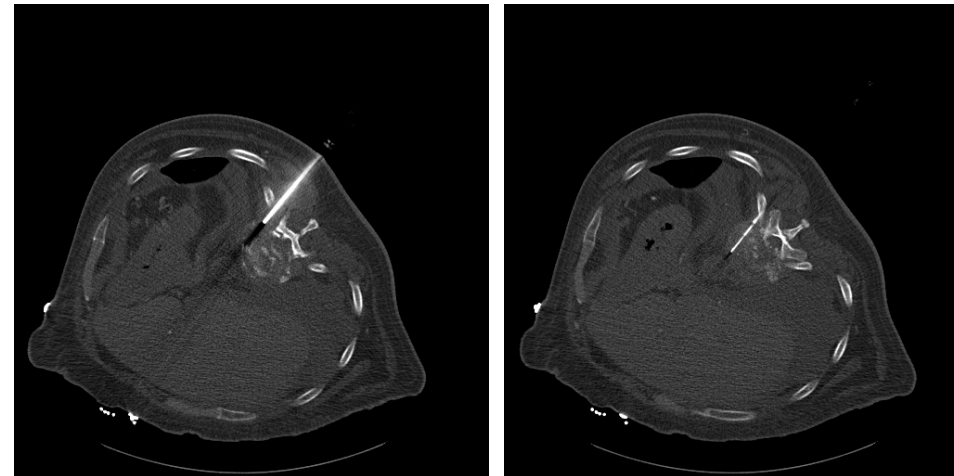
CT guided bone biopsy in a 59 year old male patient with destructive lesion in the thoracic vertebra suspicious for osteomyelitis.
